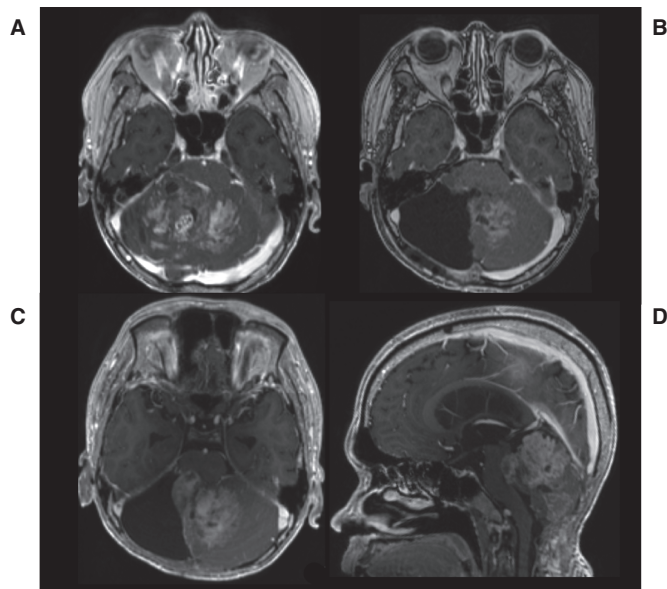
Magnetic resonance imaging (MRI) obtained prior to second surgery at our institution. Contrast-enhanced T1-weighted image acquired during admission (A), after first surgery at our hospital (B), and 6 months after first surgery (C, axial; D, sagittal).
